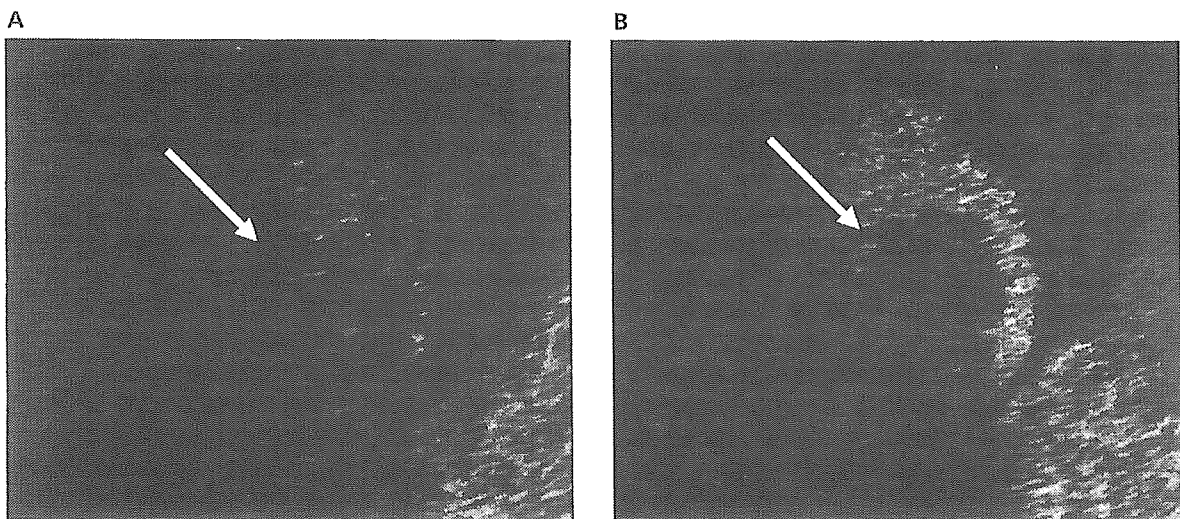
Sonographically guided RFA for ruptured HCC. A, The RFA electrode needle was inserted into the tumor along with the puncture guideline (arrow). B, After RFA, the entire tumor became strongly echogenic (arrow).
